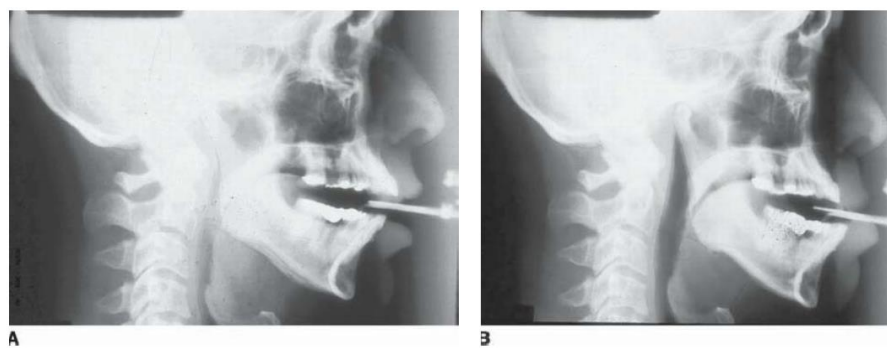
Effect of oral appliances on the airway: Lateral cephalometric radiograph in a patient with OSA, before (A) and after (B) application of a MAD. Note the enlargement of the pharyngeal airway with the oral appliance at both the retrolingual and retropalatal portions of the airway. (Images courtesy of Robert Rogers, DMD, D.ABDSM, Pittsburgh Dental Sleep Medicine.)
